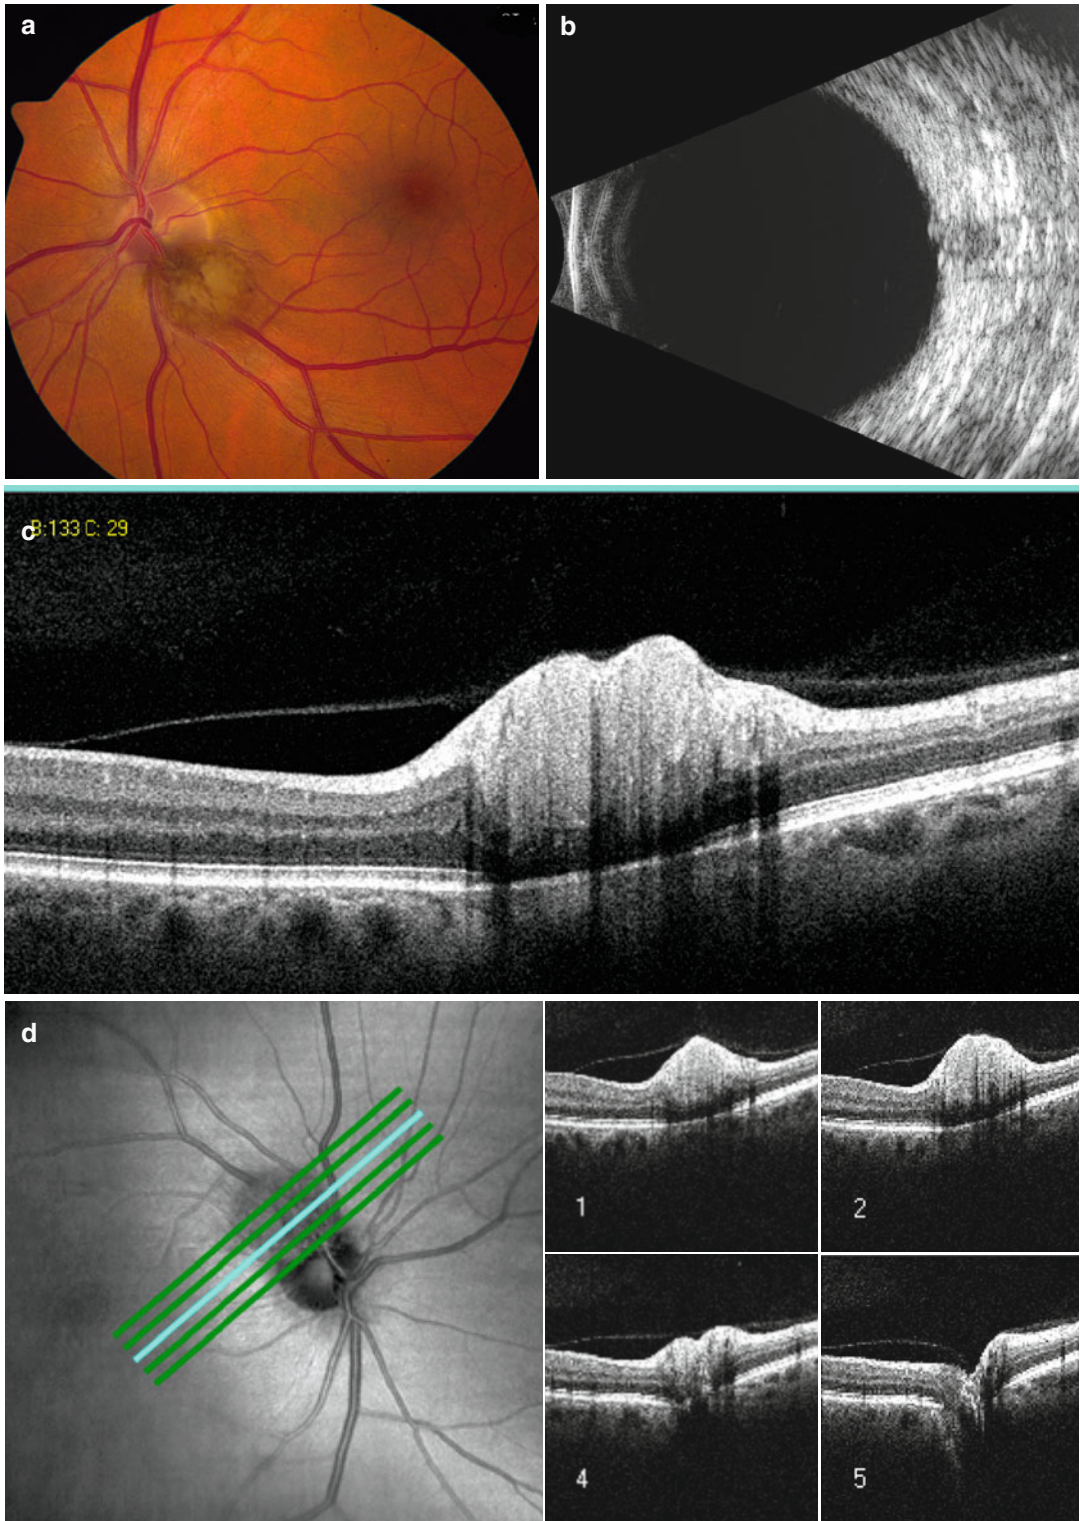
Optic disc melanocytoma. Clinical appearance (a). The lesion is barely detectable by conventional B-scan ultrasonography (b). The inner layers of retinal appear to be thickened with disorganization of outer
